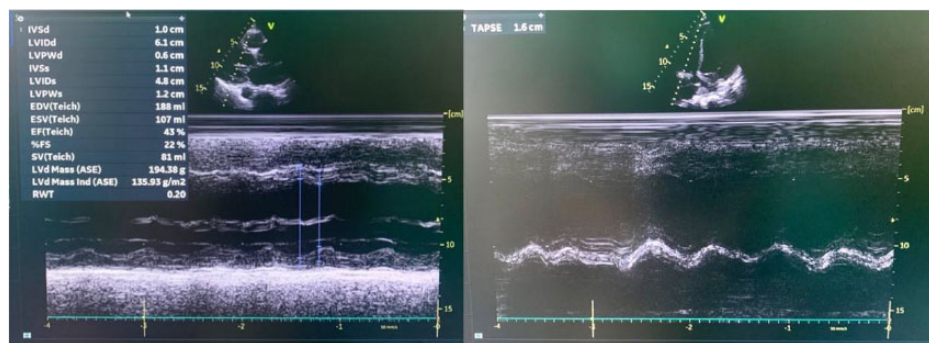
Transthoracic Echocardiography: LVEF 43 % with eccentric left ventricular hypertrophy and diastolic dysfunction grade II. And normal right ventricular systolic function with TAPSE 16mm.
